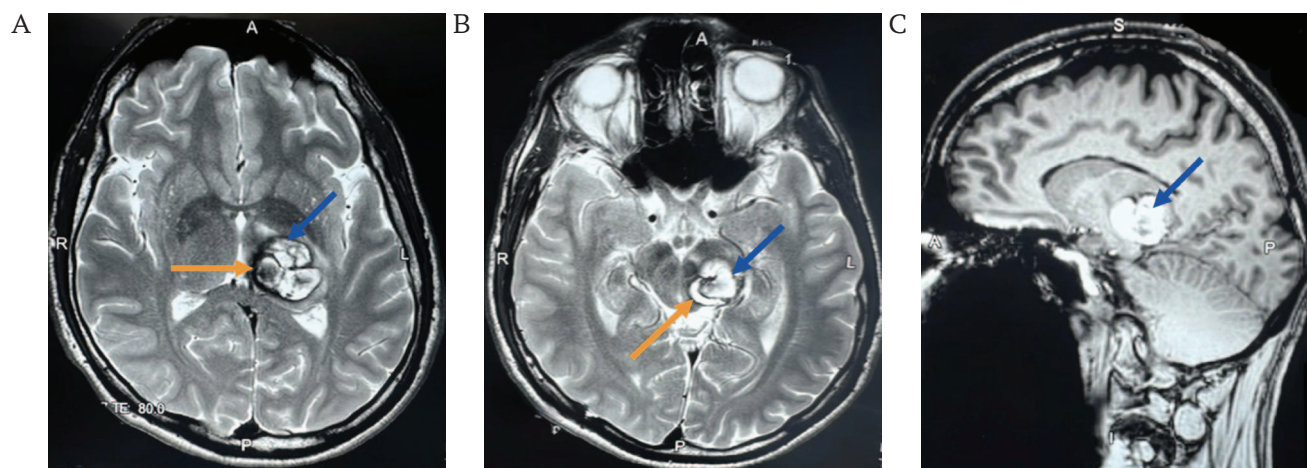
Magnetic resonance imaging of a 38-year-old patient with a cavernous malformation measuring 20x30x25 mm in the dorsal part of the left peduncle of the midbrain (May 13, 2024).
